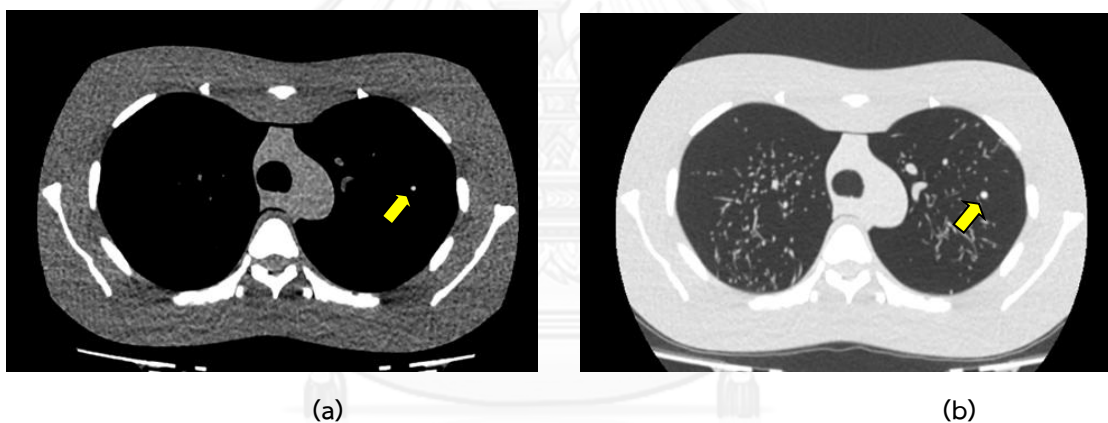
1 The chest CT with 5 mm nodule with soft tissue window (a) and lung window (b), Target SD 20, 10-400 mA, pitch 0.813 and 120 kVp
